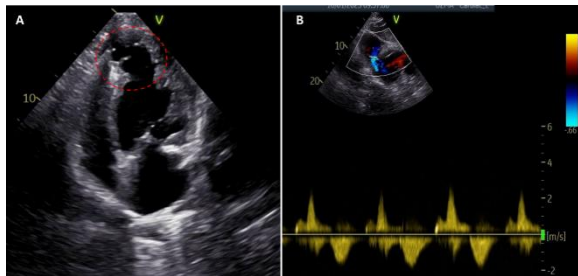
Apical four-chamber view showing pseudoaneurysm of LV apex (A) and color Doppler showing bidirectional flow across the pseudoaneurysm (B)
